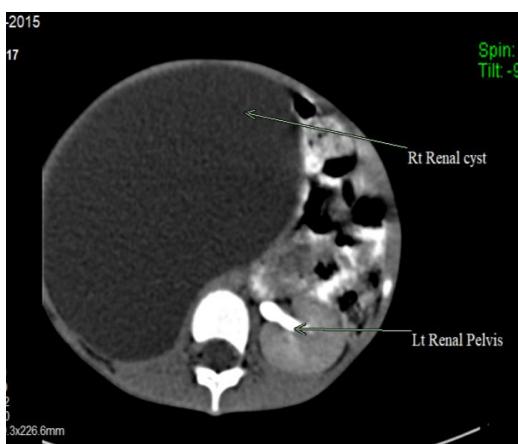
Axial view (A) CT scan urinary tract before surgery
